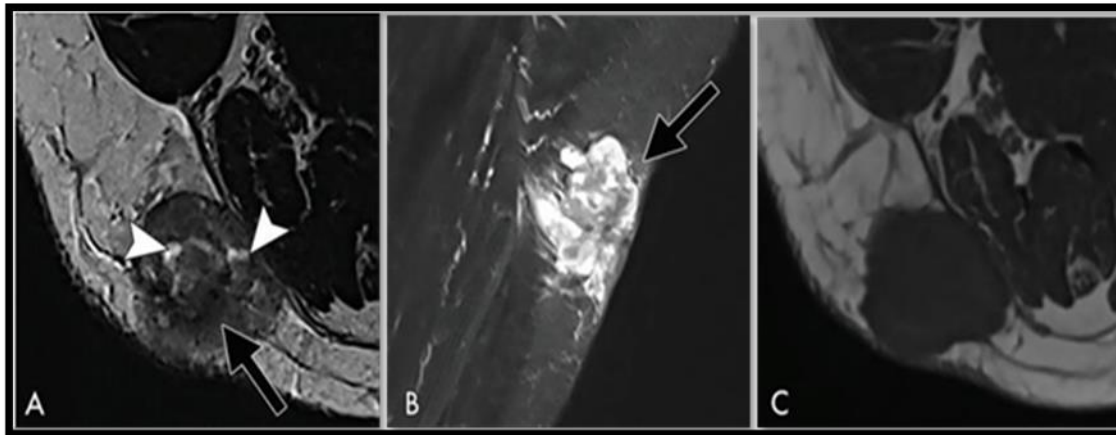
64-year-old woman with undifferentiated pleomorphic sarcoma. Tumor was located in superficial and aponeurotic tissues of the thigh. A) axial T2-weighted imaging, B) sagittal T2-weighted imaging with short TI inversion-recovery fat-suppression method, and C) axial T1-weighted imaging. Lesion exhibited heterogeneous signal intensities on at least 50% of tumor volume on T2-weighted images (black arrows), foci of necrosis [29].
